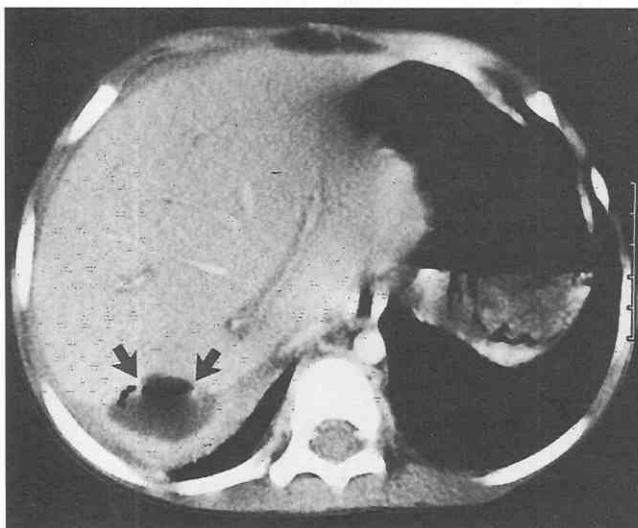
Bile leak following segmental liver transplantation. Contrast-enhanced CT image in a child with a segmental liver transplant reveals an irregular, low-attenuation collection of bile (arrows) with foci of air following anastomotic leak at the biliary-bowel anastomosis.
